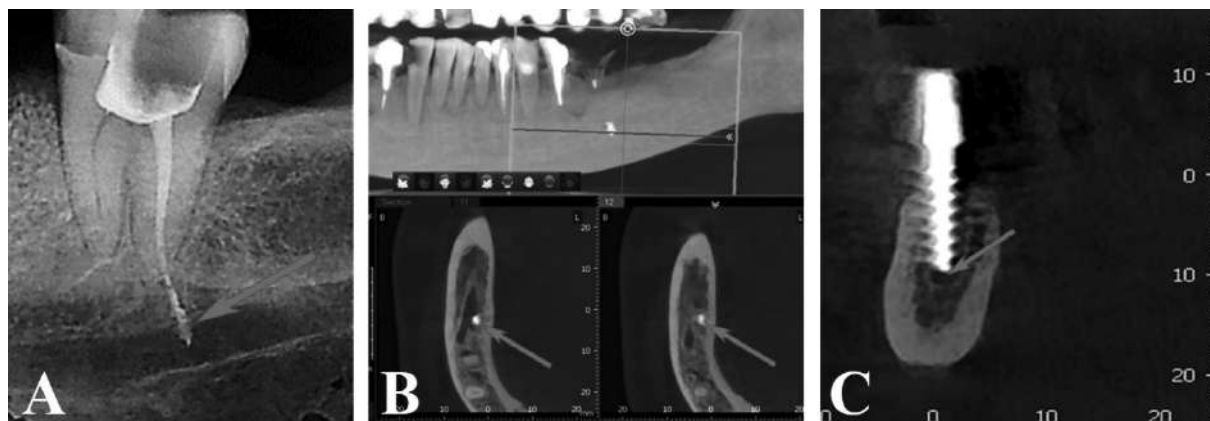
A) removal of the filling (obturation) material outside the periapical tissues by pushing it into the space of the mandibular canal; B) partial obturation of the lumen of the mandibular canal, on the right side, in the area of the furcation branch; C) partial obturation of the lumen of the mandibular canal with an implant
